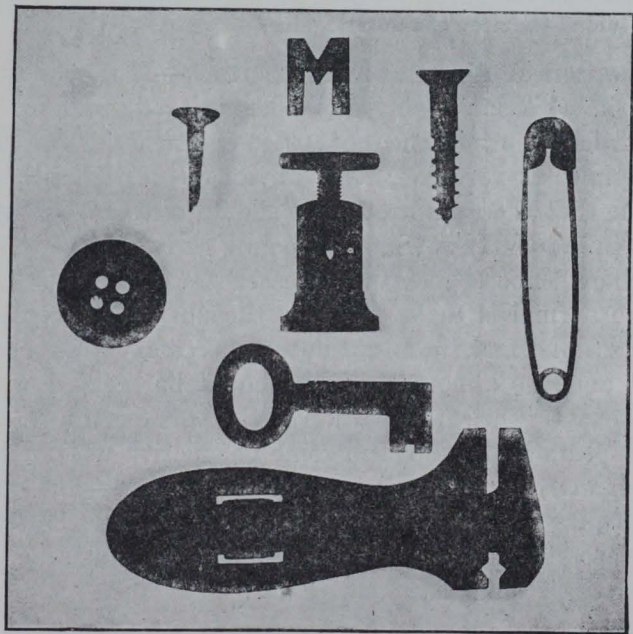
RADIOGRAM OF SAME OBJECTS IN SAME POSITION AS IN FIG. 56. BUT WITH X-RAY TUBE FOUR INCHES TO ONE SIDE.
